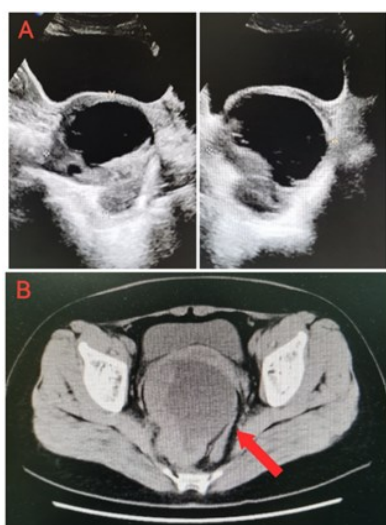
(A) Gynecologic color ultrasound revealed a solid cystic mass about $9.3 \times 8.9 \times 9.5$ cm in size behind the cervix. (B) Whole abdomen and pelvis non-contrast and contrast-enhanced CT scans demonstrate an irregular cystic-solid mass posterior to the uterus, showing ill-defined demarcation from the cervix. The solid components exhibit marked heterogeneous enhancement.
